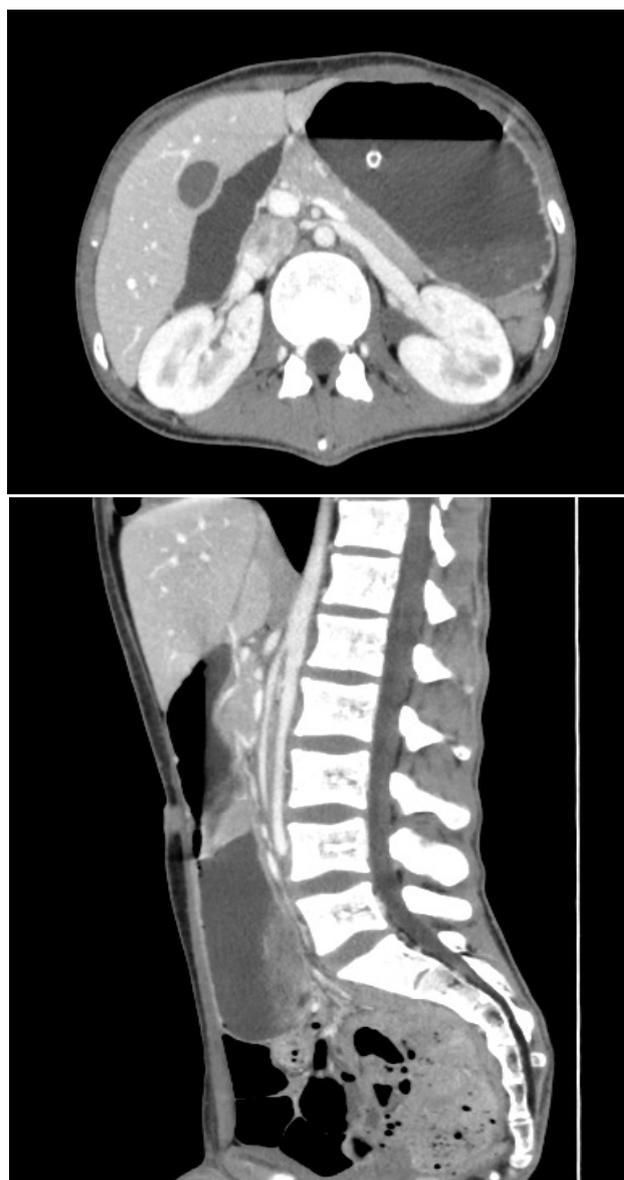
Abdominal CT scan (sagittal and axial plane) – the duodenum is compressed between the aorta and the superior mesenteric artery (aortomesenteric angle less than 14°).
